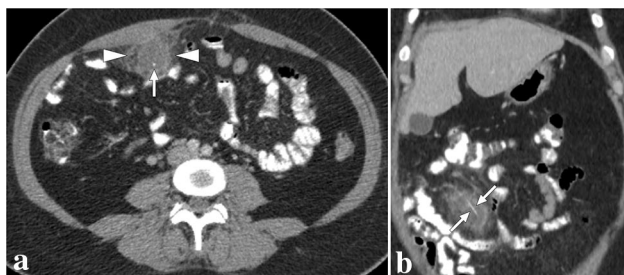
A 43-year-old female presented with acute right-sided abdominal pain. a Axial plane postcontrast abdominal CT showed ill-defined mass-like omental lesion (arrowheads) with adjacent fat stranding. Note was also made of a hyperdense dot (arrow) within the lesion. Imaging findings were suggestive of an omental infarct, and the central hyperdense dot was thought to represent a thrombosed vascular structure, although it is an atypical finding for an omental infarct. The patient developed fever and progressively increasing abdominal pain despite maximum supportive treatment and finally underwent a laparoscopic excision to rule out secondarily infected omental infarct. Pathological evaluation revealed a nonneoplastic inflammatory omental mass containing a fishbone and foreign body reaction. b Based on pathological findings, a retrospective evaluation on the coronal plane demonstrated linear hyperdensity representing the fishbone (arrows)
